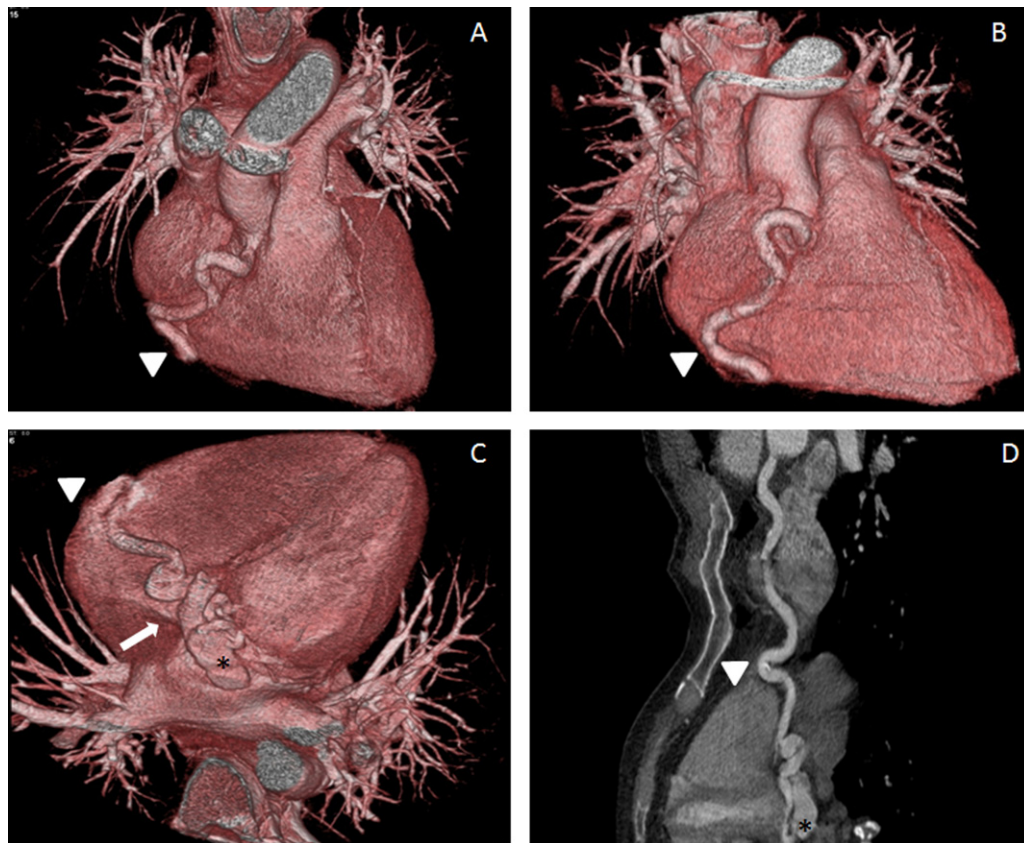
(A–C) Volume rendered images from coronary computed tomography angiogram showing a tortuous and largely dilated RCA (arrow heads) most prominent on the inferior border of the heart. The asterisk points out the fistula communication between the RCA and coronary sinus. The arrow points out the entry of the sinus into the right atrium. The right atrium appears mildly dilated. (D) Curved planar reformatted image showing a dilated tortuous RCA draining distally into the coronary sinus. RCA, right coronary artery.
